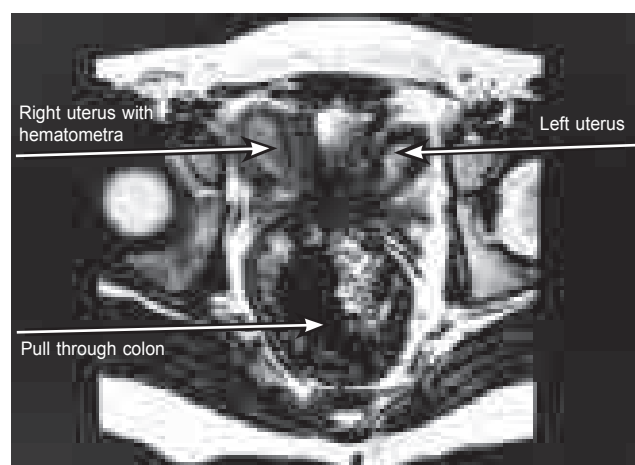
MRI pelvis showing uterus didelphys with obstructing hemivaginal septum with right hematometra and hematosalpinx.
